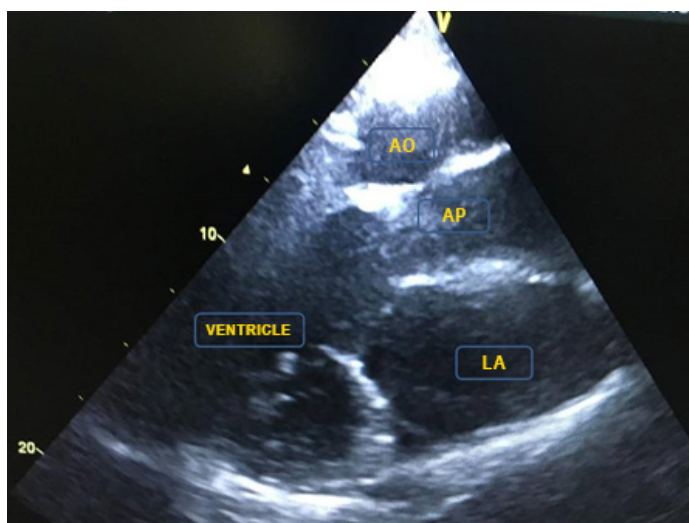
Long axis, parasternal view showing the transposition of the great arteries. 254x190mm (96x96 DPI).
